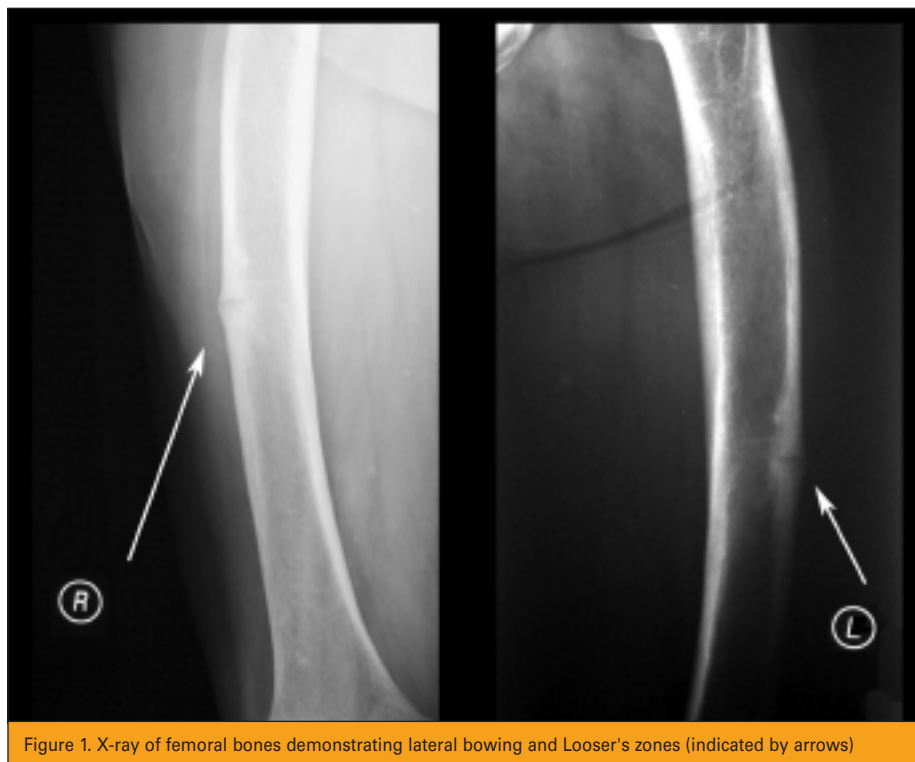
X-ray of femoral bones demonstrating lateral bowing and Looser's zones (indicated by arrows)
